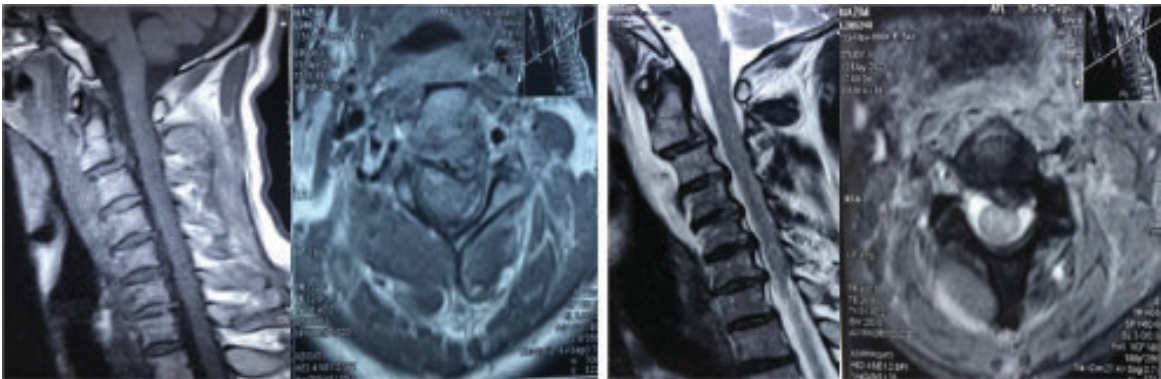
Preoperative MRI of cervical spine
